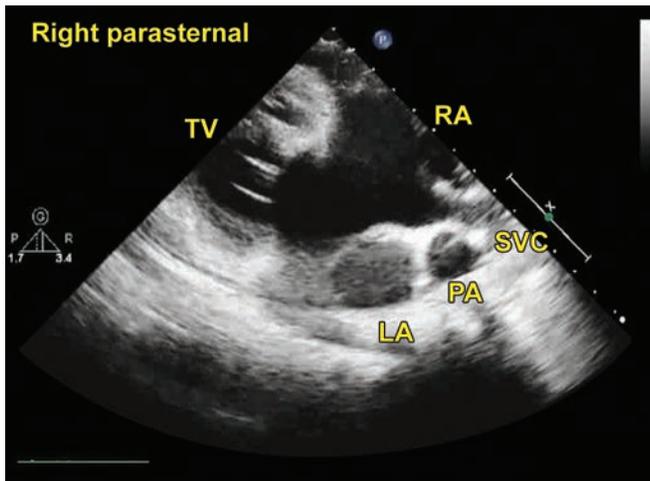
Right parasternal examination. Initially, the atrial septum next to the SVC appeared intact but slight transducer angulation showed the sinus venosus defect which was subsequently confirmed by color Doppler.
